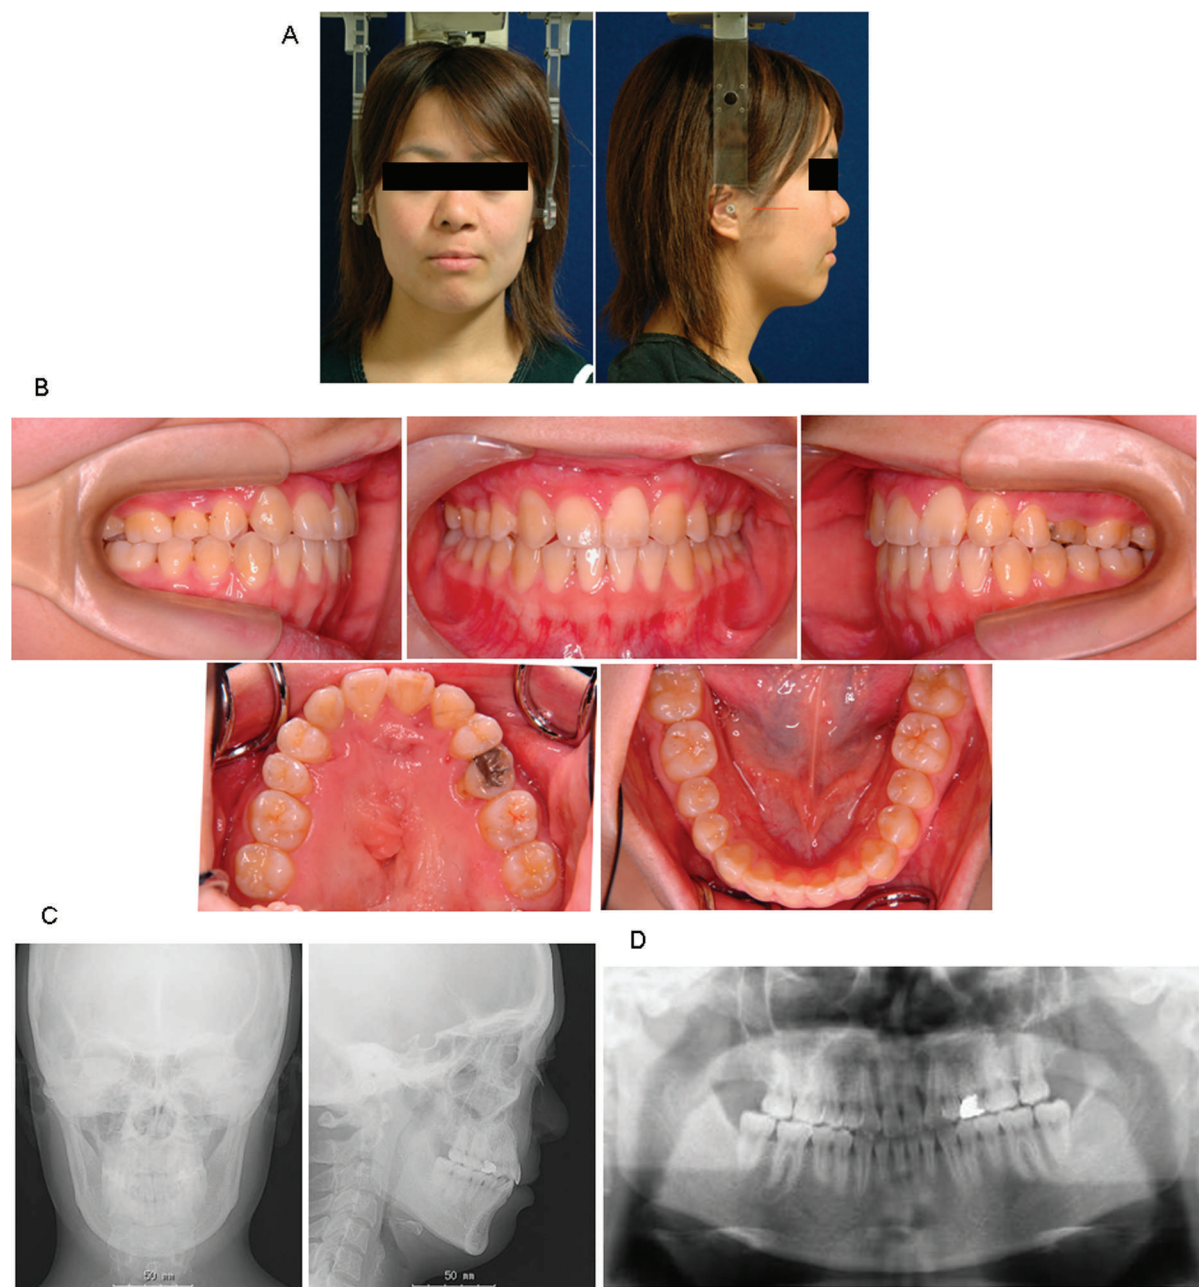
Postretention records (age, 22 years 1 month). (A) Facial photographs. (B) Intraoral photographs. (C) Frontal and lateral cephalograms. (D) Panoramic radiographs.
